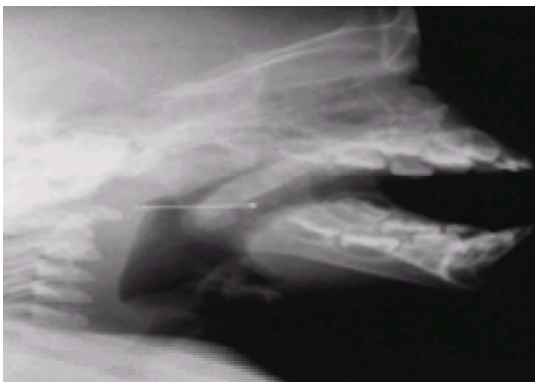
Lateral neck radiograph of a straight pin lodged in posterior pharyngeal wall.
